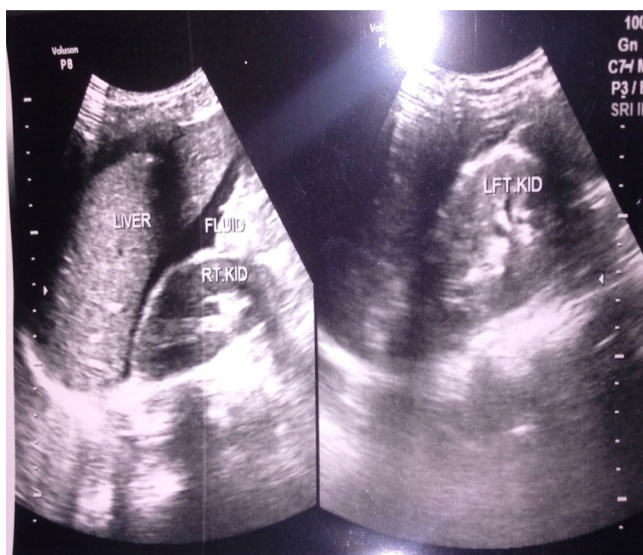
Abdominal ultrasound scan showing free peritoneal fluid.
